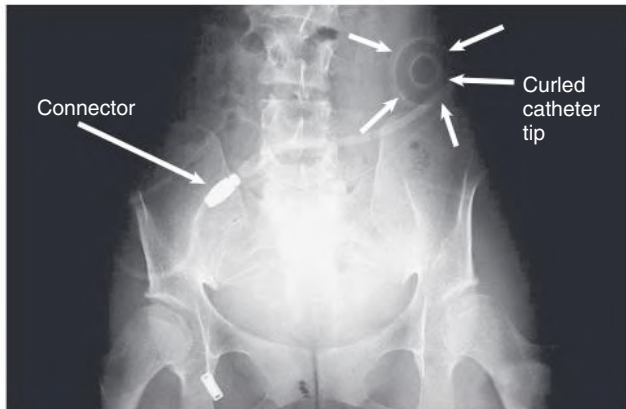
Catheter Malposition. Plain radiograph of the abdomen with curled catheter (*arrows*) misplaced in the upper left abdomen.
